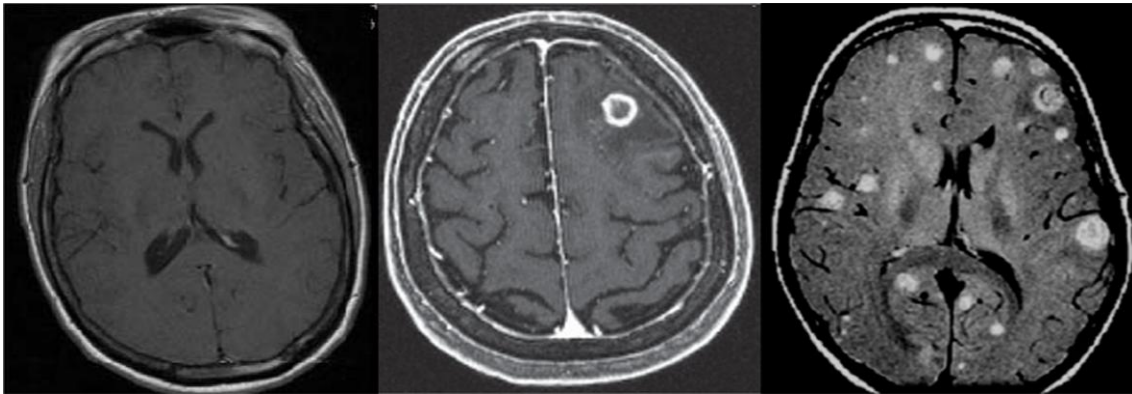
MRI scan of brains
